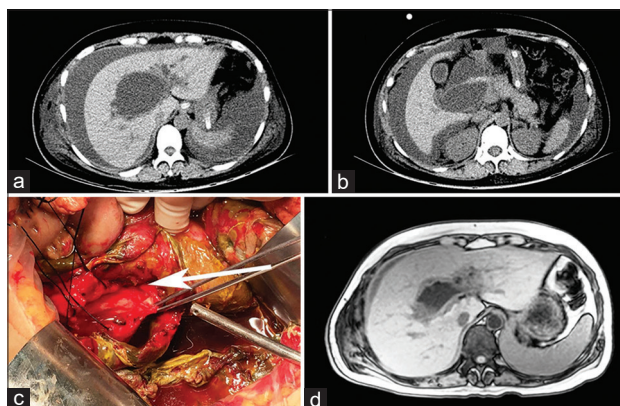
Contrast enhanced computed tomography on admission showing a huge cystic mass in the porta hepatis area and a mixed-density mass in the hepatoduodenal ligament area extending down to the level of the pancreatic head, which proved to be a type IVa choledochal cyst (a), and adhesions under the liver and surrounding the duodenum, with a large amount of bile-like fluid and necrotic substance (b), respectively. (c) Surgical exploration revealed a ruptured choledochal cyst (white arrow) and biliary peritonitis. (d) Magnetic resonance cholangiopancreatography of the choledochal cyst 3 weeks after the initial operation.
